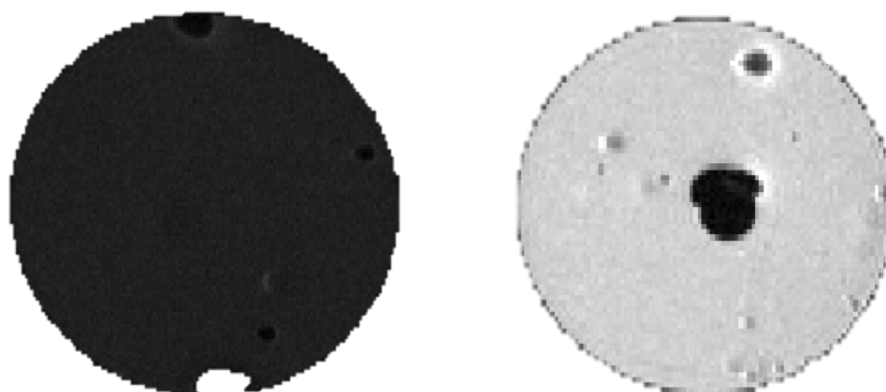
T1-weighted images of unlabeled (Left) and Gd-labeled dietgel (Right).
